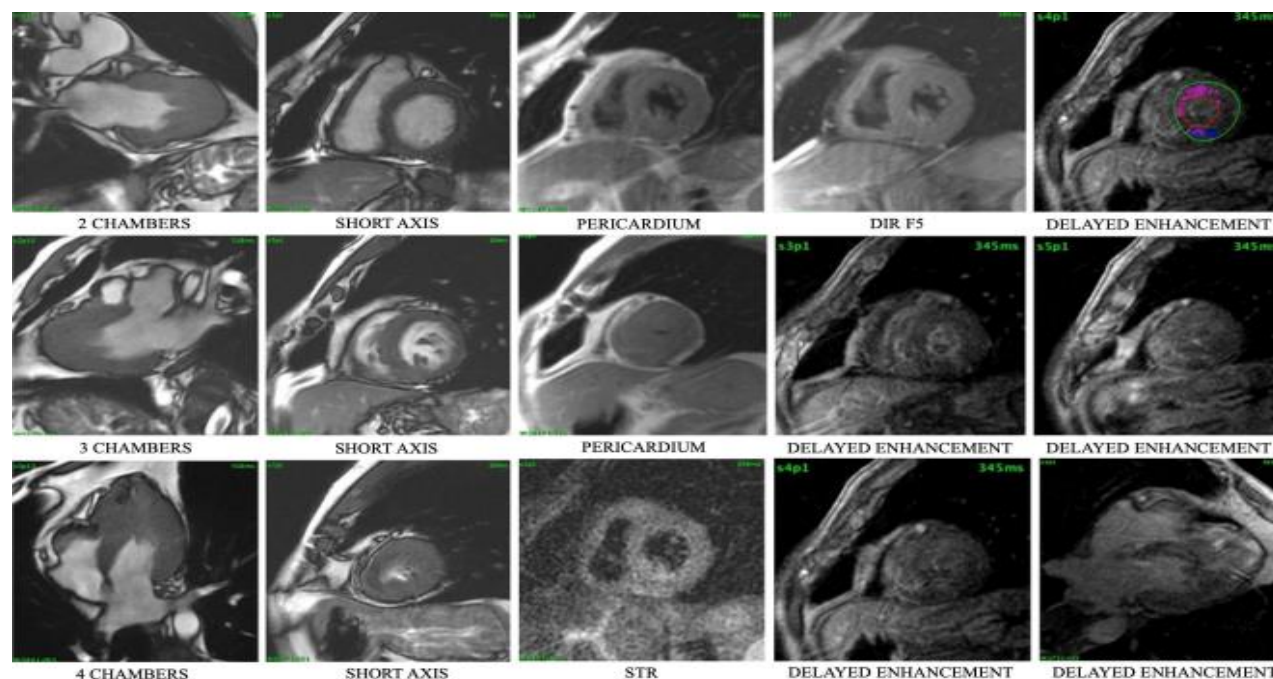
Cardiac MRI scanning of patient with Noonan syndrome with multiple lentigines
